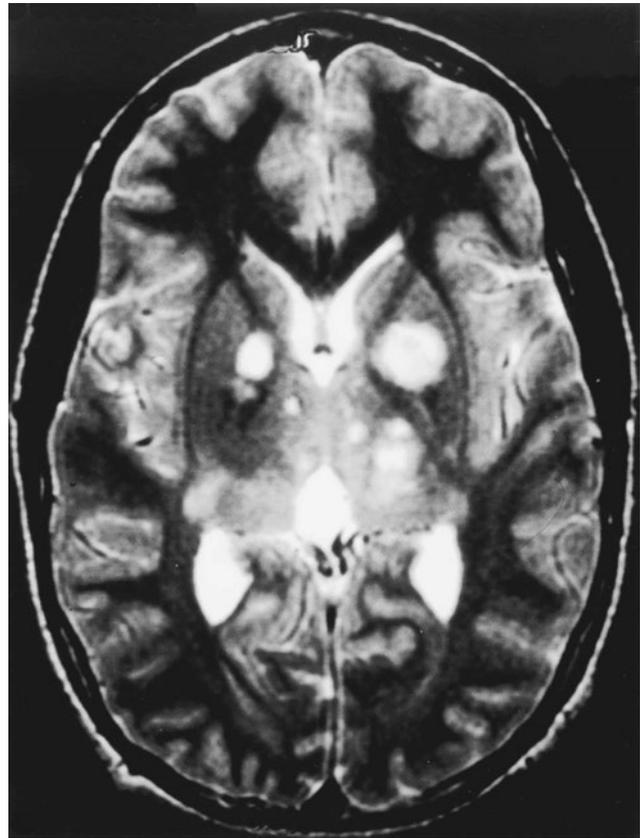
This axial T2-weighted magnetic resonance image demonstrates the characteristic areas of T2 signal abnormality that are commonly detected within the basal ganglia and occasionally within the cerebellum and other regions of the brain in patients with neurofibromatosis type 1.
